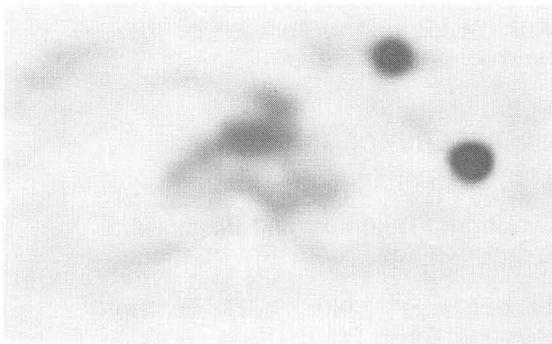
PET scan of the same patient shown in fig. 1 is displayed. The two dark spots located in the patient right breast areas where ^{18}F has accumulated, are diagnosed as cancerous cells and were later verified by needle biopsy and pathology. This remarkable clarity in diagnosing breast cancer with PET scans have in part motivated the subject of this paper, increased reliability in the production of FDG by a dual redundant chemistry station.
